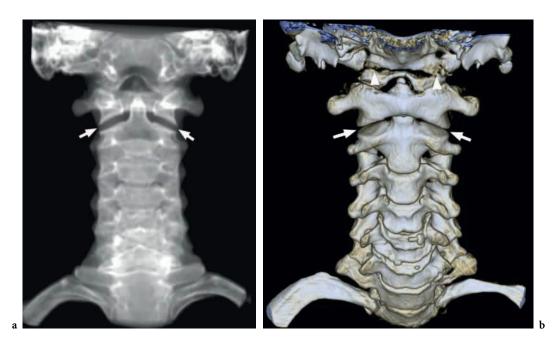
Coronal volume-rendered multi-detector row CT images in a patient with a high speed motorcycle accident to the upper cervical spine and the occipito-cervical junction. a Volume-rendering reconstruction with a low bone opacity shows a widening of the atlanto-axial junction as defined by a subluxation (arrows), which could not be detected in the axial source images. b Oblique coronal reformatted volume-rendering reconstruction shows an additional fracture of the occipital condyles (arrowheads)
